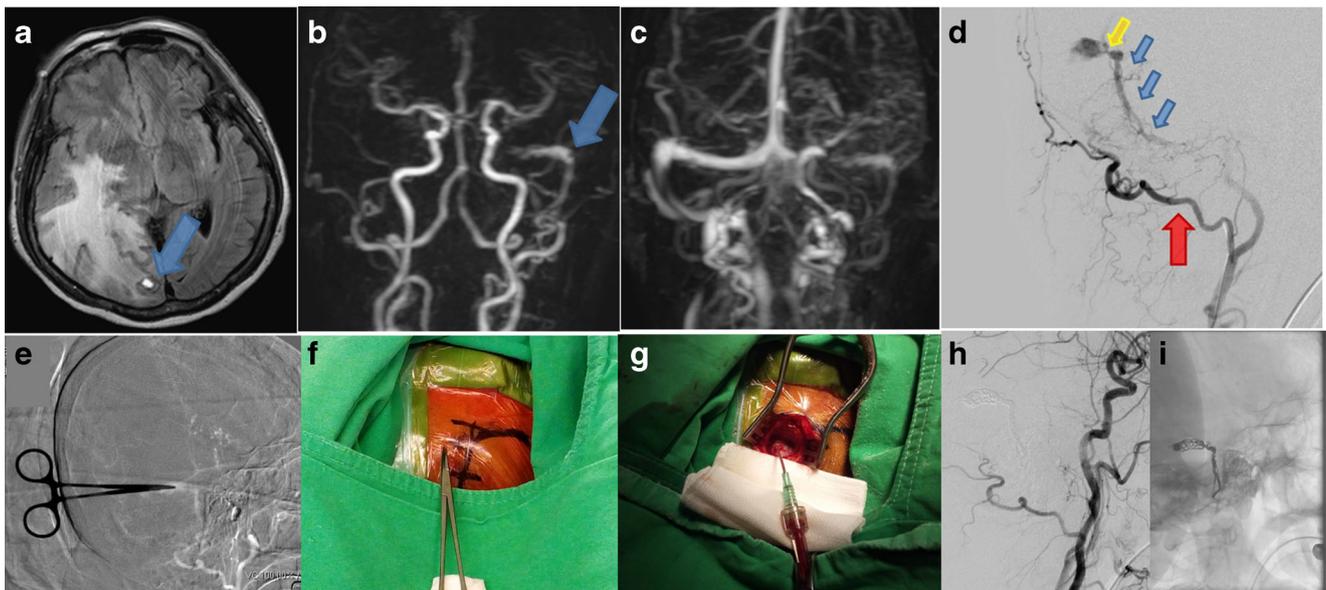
Direct puncture of the transverse sinus for DAVF embolization via a right occipital burr-hole in the hybrid OR. (Level A) a Fluid attenuation inversion recovery sequence of MR imaging revealed cerebral edema at the right occipital region with a small intracerebral hemorrhage (blue arrow) caused by venous hypertension owing to the DAVF. b 4D contrast-enhanced MR angiography indicated possible DAVF at the right transverse-sigmoid sinus. c In the late phase of the same sequence, cortical venous regurgitation was noted at the right occipital region, and the right internal jugular vein was not patent. d In the early arterial phase, DSA image of the right occipital artery (red arrow) showed multiple fistula points at the right sigmoid sinus (blue arrows). Due to occlusion
